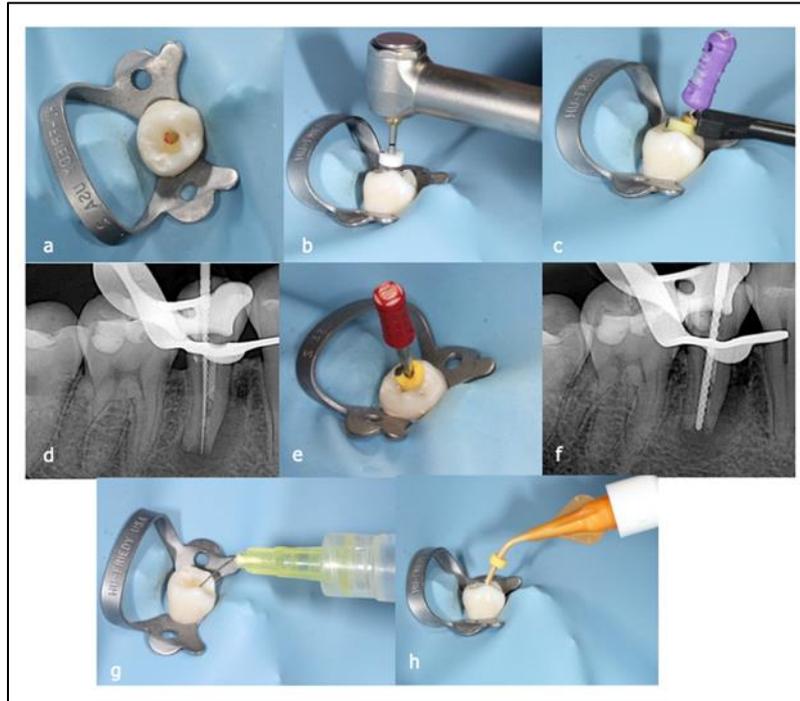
(a) Temporary filling removal, (b) Removal of previous gutta percha and sealer, (c) Working length measure, (d) Periapical radiographic working length confirmation, (e) apical gauging, (f) Periapical radiographic apical gauging confirmation, (g) sequence irrigation, (h) bioceramic dressing application
